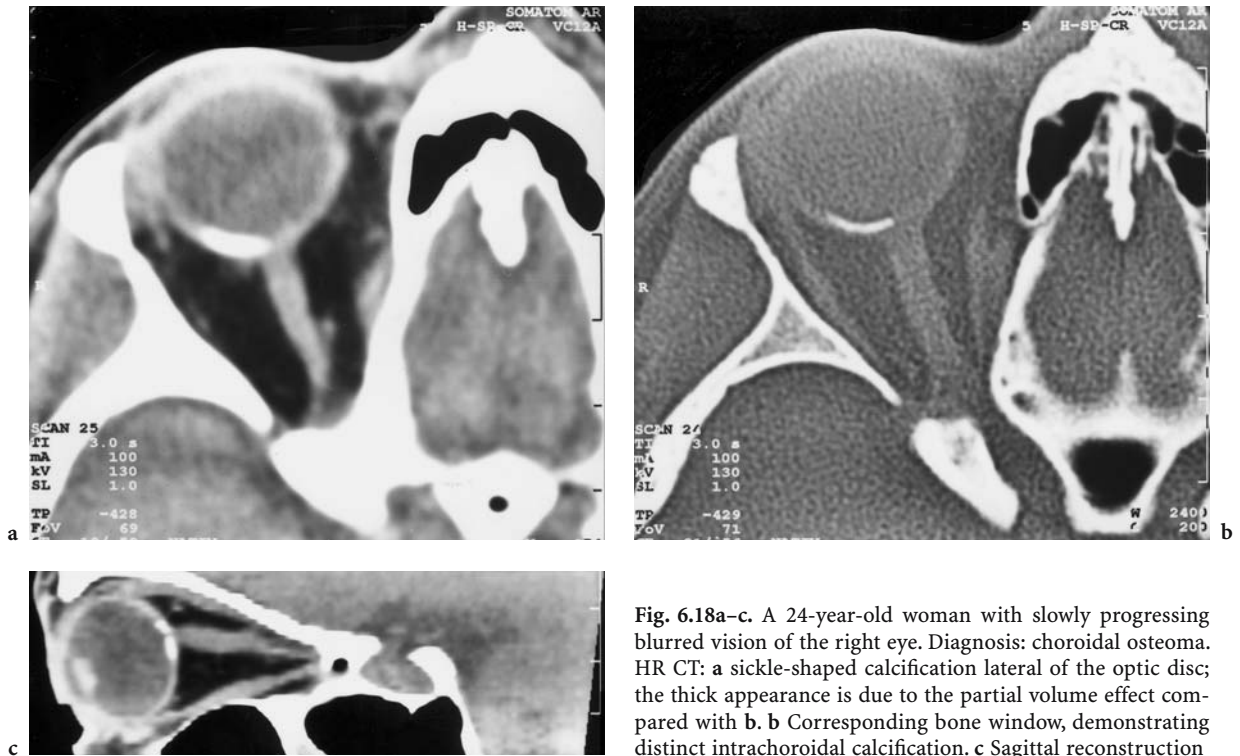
A 24-year-old woman with slowly progressing blurred vision of the right eye. Diagnosis: choroidal osteoma. HR CT: a sickle-shaped calcification lateral of the optic disc; the thick appearance is due to the partial volume effect compared with b. b Corresponding bone window, demonstrating distinct intrachoroidal calcification. c Sagittal reconstruction
